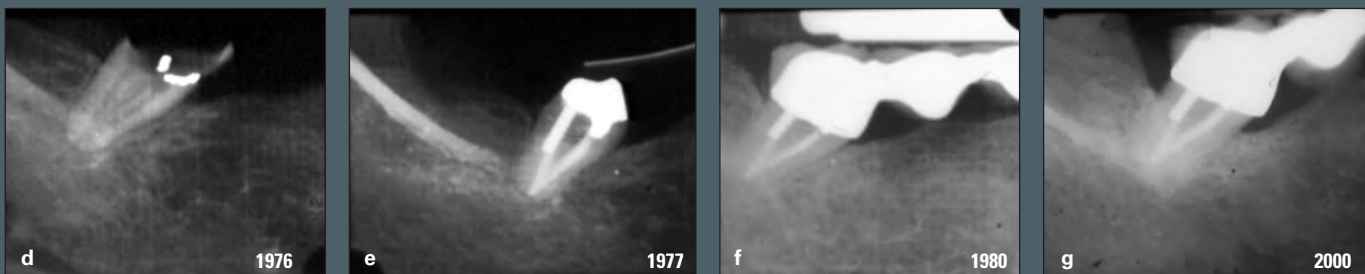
(a and b) This case predates osseointegration, and crown lengthening was necessary to construct a restoration with margins on healthy tooth structure. (c) The sutured position of the flaps. (d to g) Radiographs from 1976, 1977, 1980, and 2000, respectively. The tooth has served the patient's masticatory needs for 24 years.
